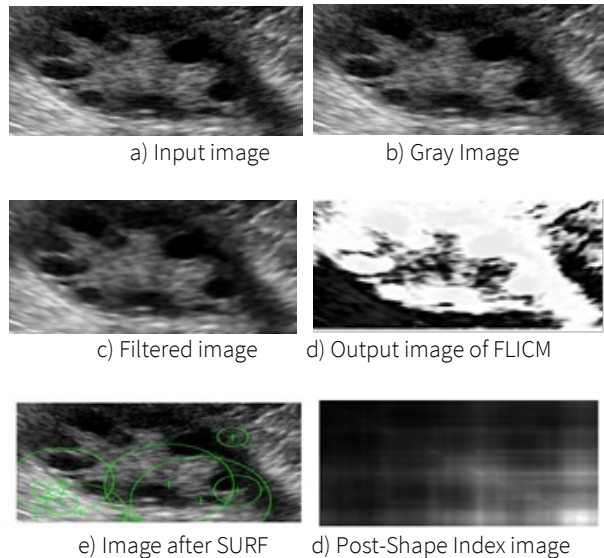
Experimental outcomes of Ultrasound images a) input, b) Gray conversion, c) Filtered output d) FLICM output e) Image after SURF f) Post-Shape Index image
